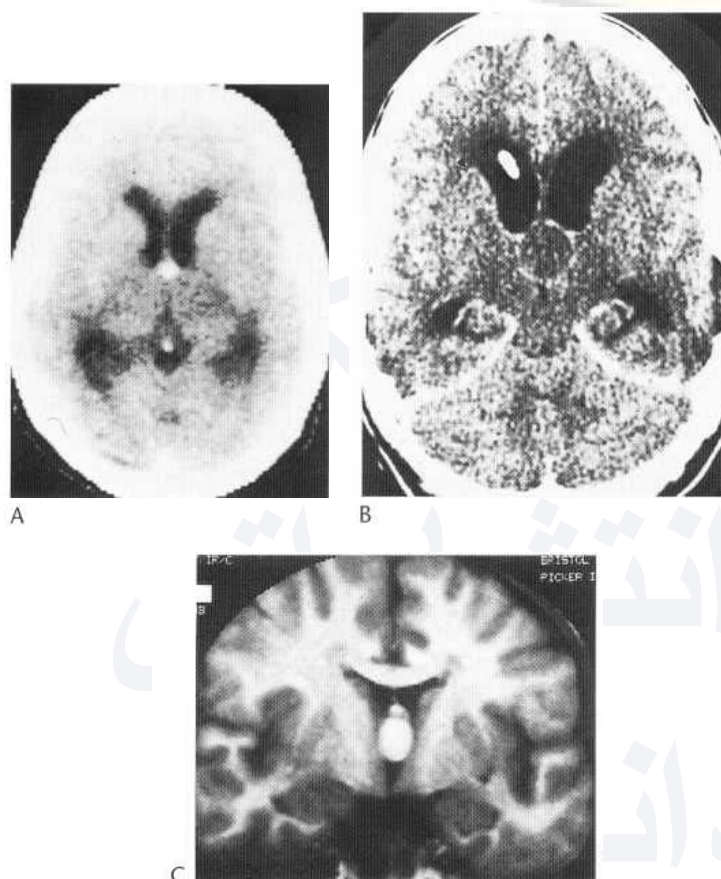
Colloid cysts. (A) Small high-density cyst at base of septum pellucidum. This is the classic appearance seen in most cases. (B) Isodense cyst with marginal enhancement after contrast medium—a rare variant. (C) Coronal MRI study (T₂-weighted) shows the cyst as a high-signal lesion in the third ventricle. (Courtesy of Dr Gordon Thomson and Bristol MRI Centre.)
